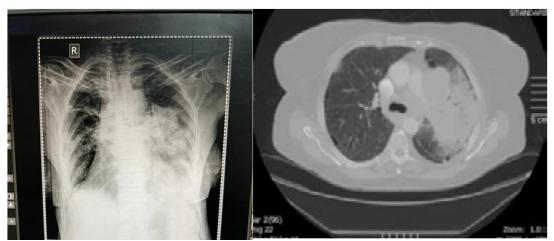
Chest X-ray (CXR) showing a homogeneous opacity in the left lower zone. Figure 2: Contrast-enhanced computed tomography (CECT) of the chest demonstrating a large, heterogeneously enhancing consolidation in the left lower zone, with cutoff of the left main bronchus.
